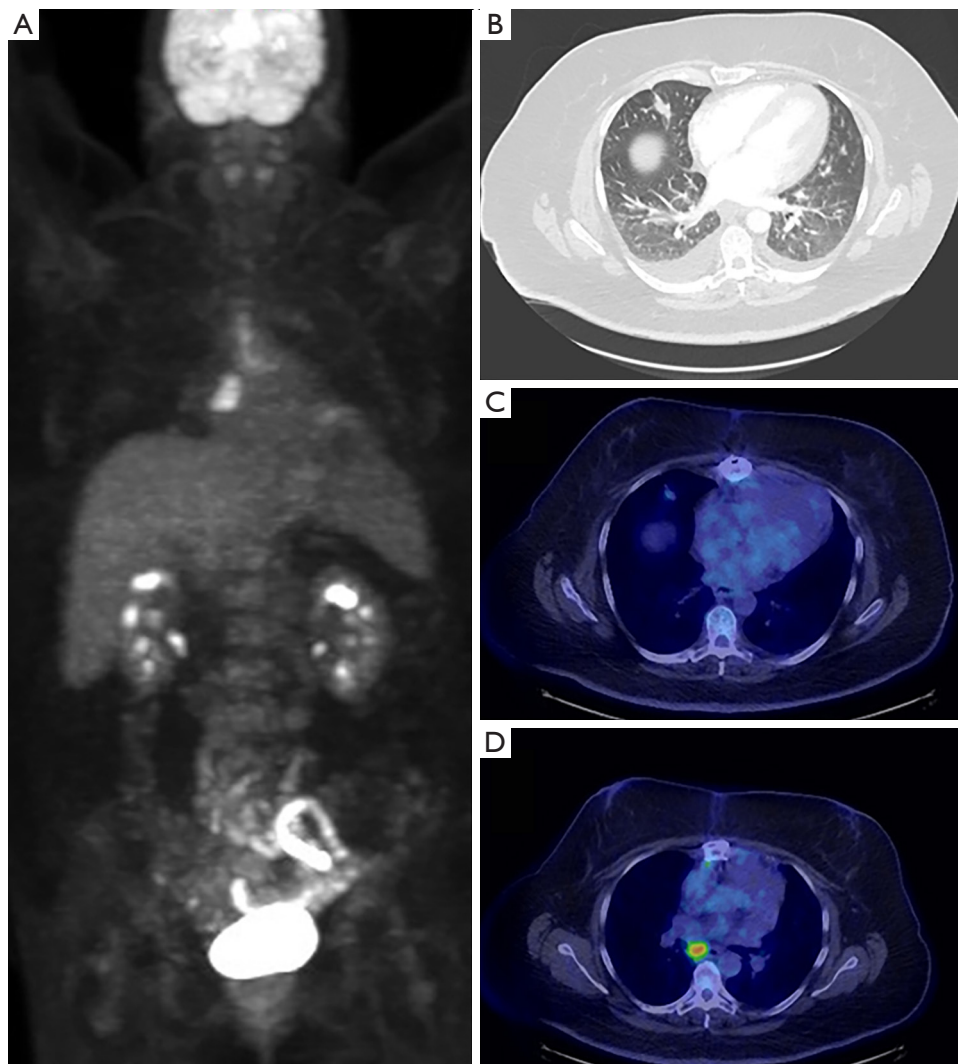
A 58-year-old female with incidentally discovered right middle lobe pulmonary nodule found on a CTA of the chest performed to evaluate for pulmonary embolus. Follow up CT 1 month later showed that the nodule remained, therefore FDG PET/CT was obtained (A). The pulmonary nodule (B) demonstrated low-level FDG uptake (C), and an FDG avid right mediastinal lymph node (D) was also noted. Given relative discrepancy with greater uptake in the lymph node than in the nodule, this was initially favored to represent granulomatous inflammation rather than malignancy, however, biopsy of the lymph node revealed metastatic lung adenocarcinoma.
